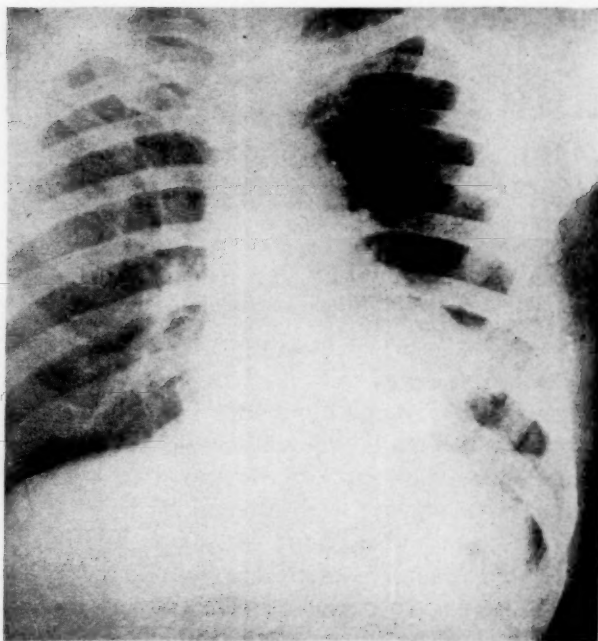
X-ray taken before radiation therapy, Case 1.
